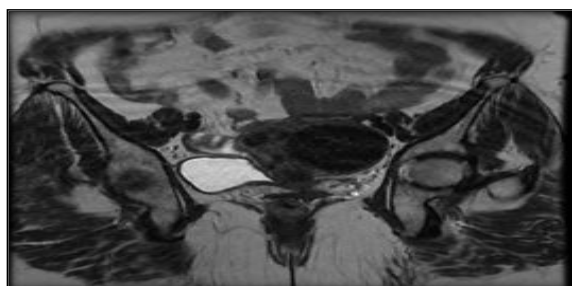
Funaki Type II — Coronal T2-weighted MRI pelvis. The uterine fibroid shows signal intensity lower than myometrium but higher than skeletal muscle, consistent with intermediate cellularity (Funaki Type 2)
